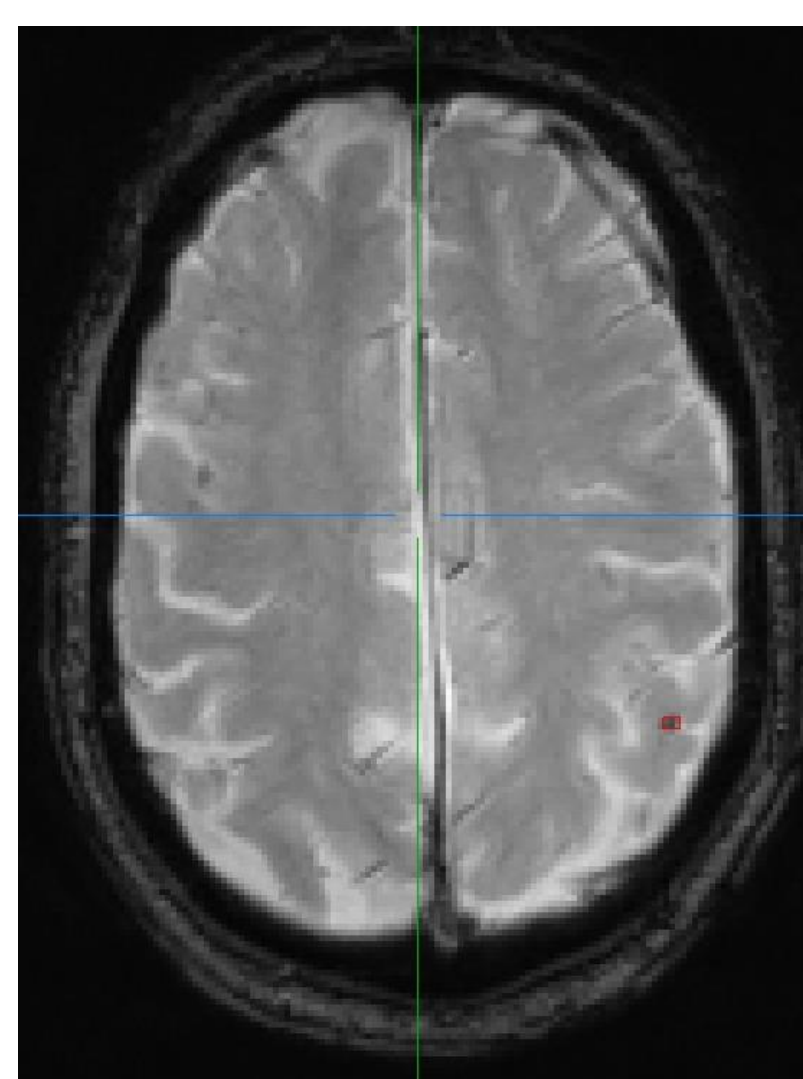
A microbleed (circled in red) in a T2S MRI images
